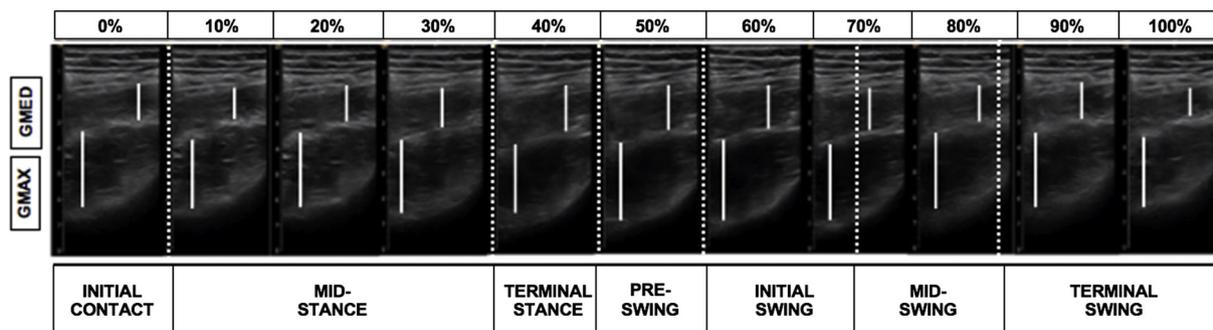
11-Point Frame Reduction of Gluteal Ultrasound Images. Images Plotted Across the Walking Gait Cycle.³⁰
